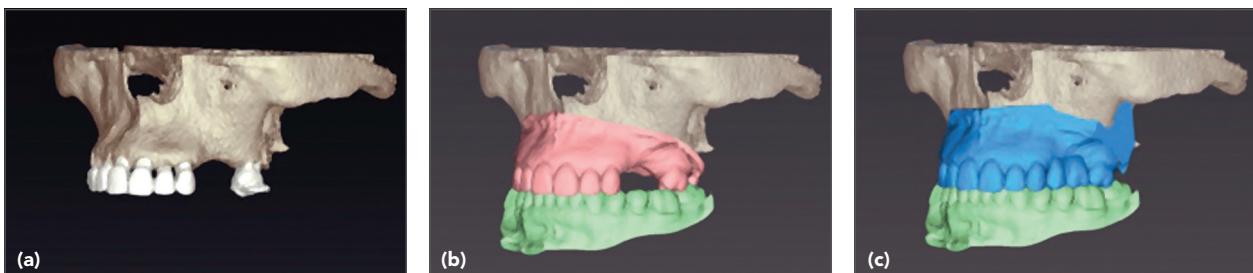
(a) Postsegmentation 3D rendering of maxillary complete-arch CBCT scan. (b) Digital diagnostic scans registered onto CBCT scan. (c) Digital wax-up registered onto CBCT scan.
